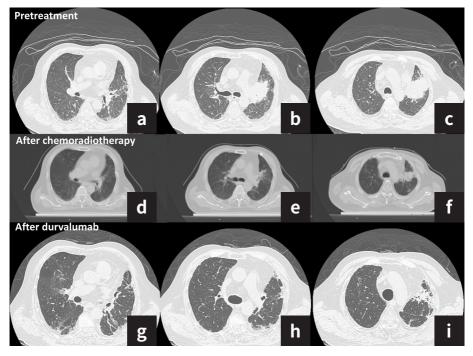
Computed tomography revealed a mass over the left upper lobe with mediastinal nodes (a)-(c), partial response after chemoradiotherapy (d)-(f), and stable disease with durvalumab treatment (g)-(i).
